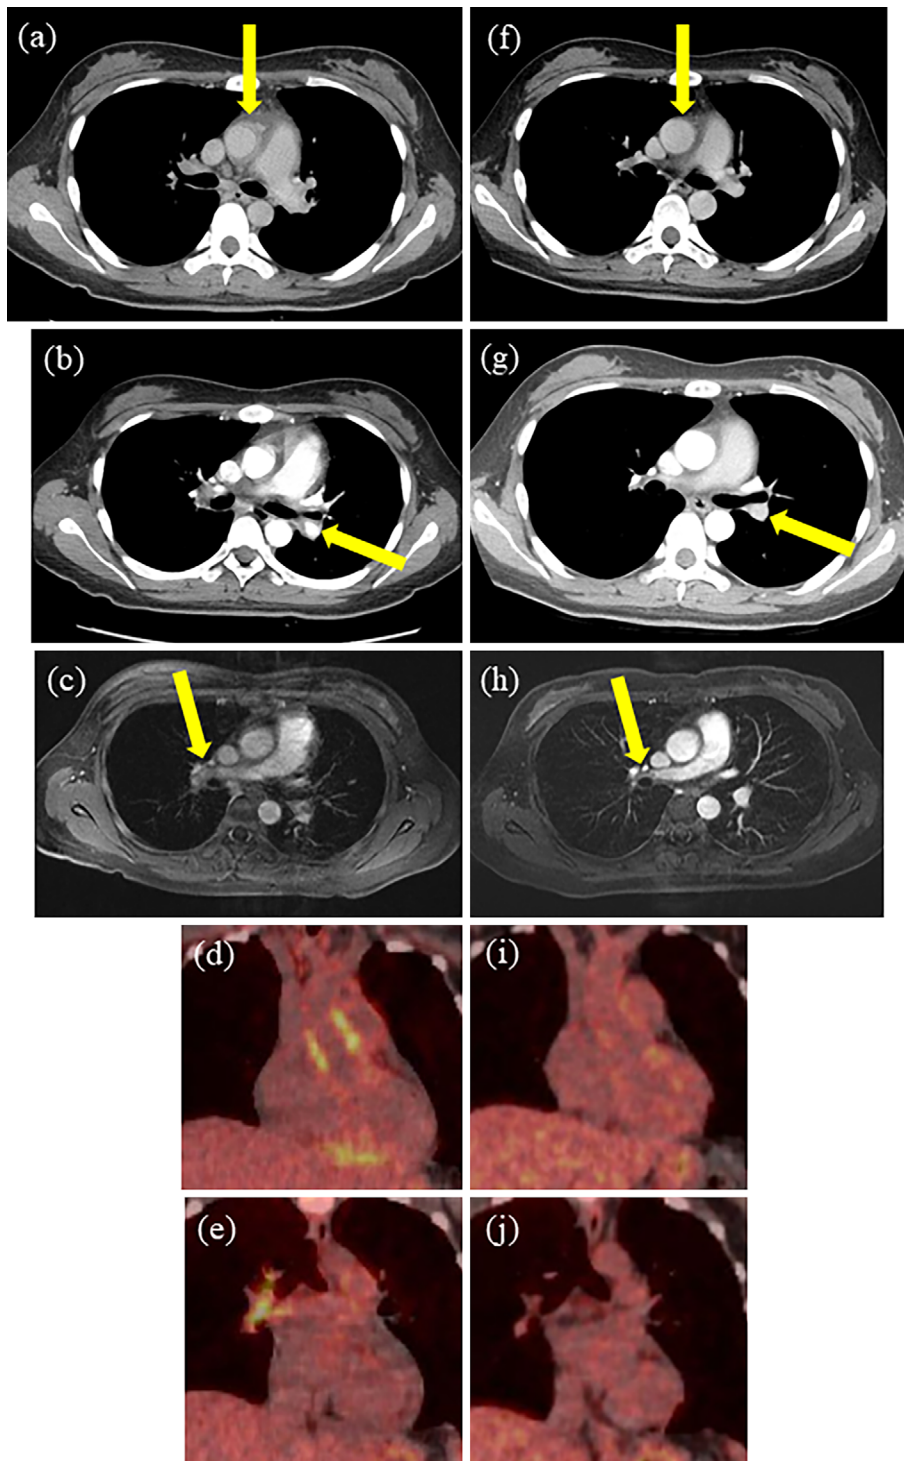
Imaging findings of Case 1. (a, b) Contrast-enhanced computed tomography showed enhanced wall thickening and stenosis of the ascending aorta and left pulmonary artery without thrombosis (arrows). (c) Contrast-enhanced magnetic resonance imaging (MRI) showed enhanced wall thickening of the right pulmonary artery without thrombosis (arrow). (d-e) Fluorodeoxyglucose (FDG)-positron emission tomography demonstrated an increased FDG accumulation in the ascending aorta, right ventricular myocardium, and right pulmonary artery. (f-j) After four weeks of treatment, all imaging abnormalities were improved.
